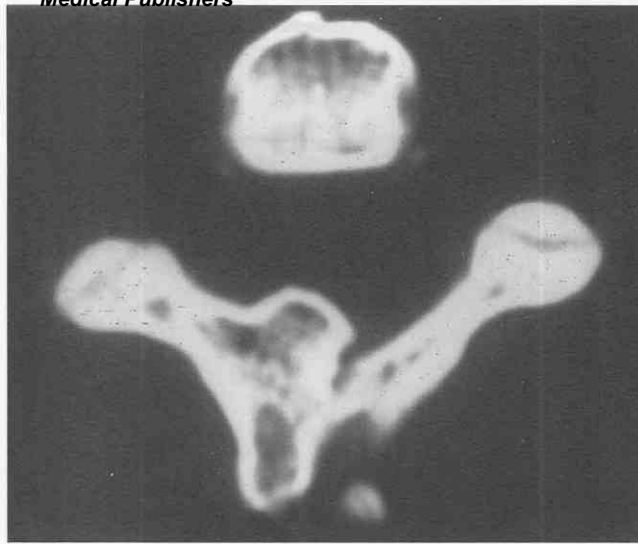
Axial CT image through an osteochondroma involving the spinous process and lamina of a vertebral body. This image demonstrates continuity of the cortex and marrow between the lesion and the vertebra.
